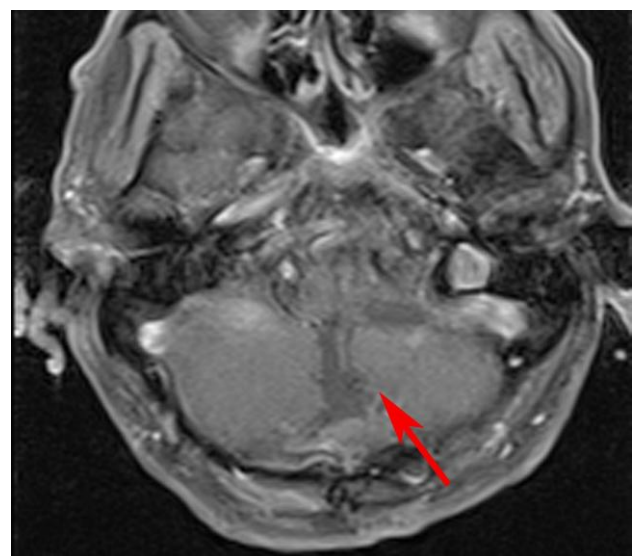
Postoperative magnetic resonance imaging, T1 gadolinium-enhanced sequence, the tumor is entirely resected, and the cavity is marked with the red arrow
